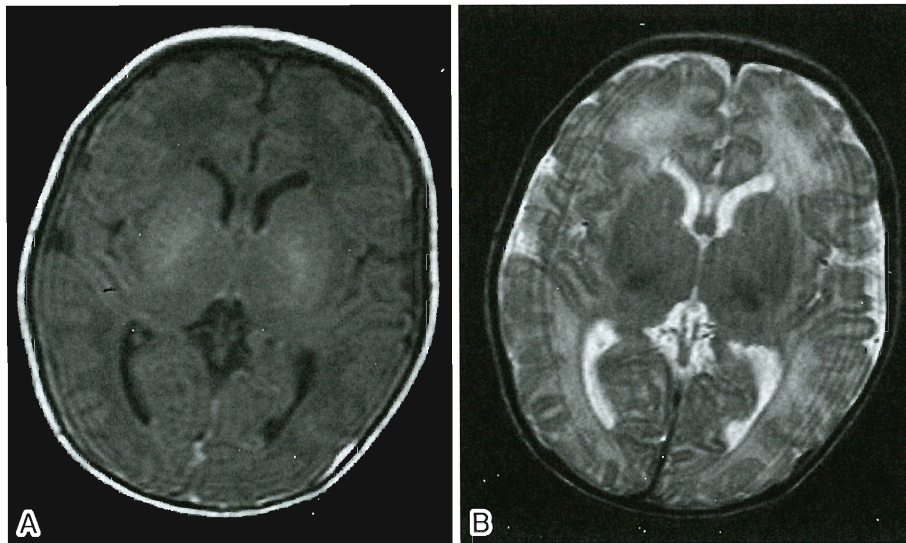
MR images of Patient 1
